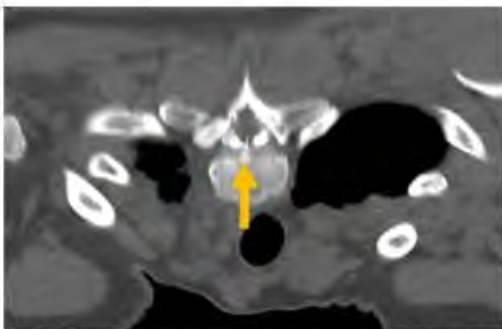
Dynamic CT myelogram with the patient in prone positioning shows focal extravasation of contrast into the epidural collection at T1-T2, identifying the level of the leak.
